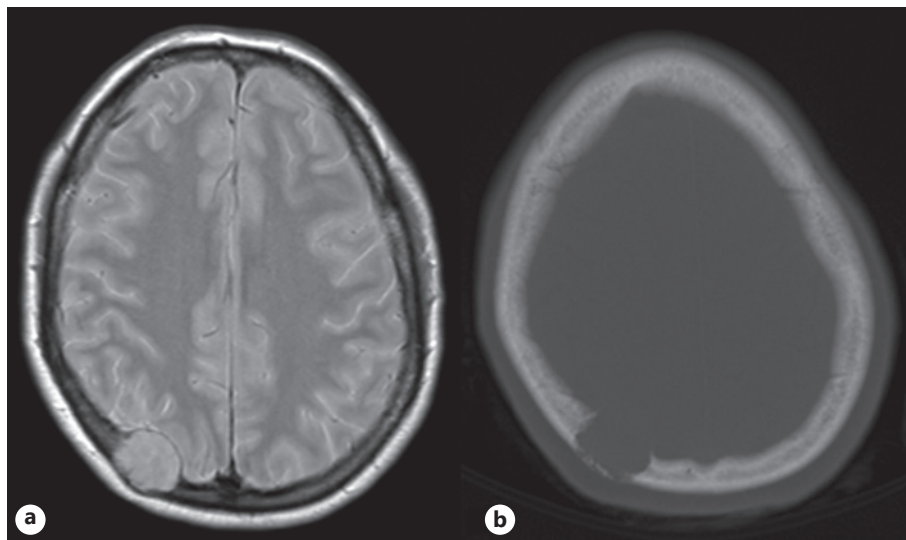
a Preoperative cranial MRI (T1 sequence) revealing a well-defined, isointense lesion at the right parietal bone with endo and exocranial extension. b Preoperative cranial CT scan (bone window) showing a lytic lesion at the right parietal bone with erosion of both cortical layers.
